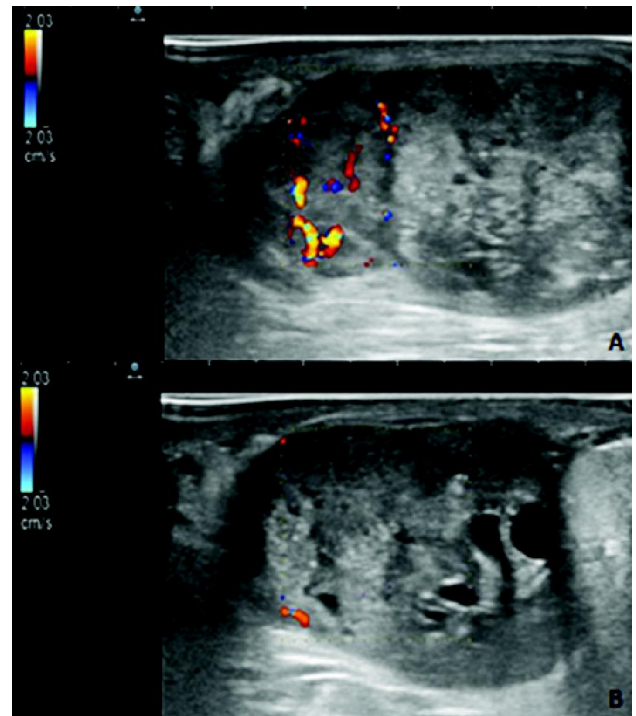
Colour Doppler of left scrotum. (A) Longitudinal section of left epididymal head showing mild peripheral and central vascularity. (B) Longitudinal section of left testis showing mild peripheral vascularity.
